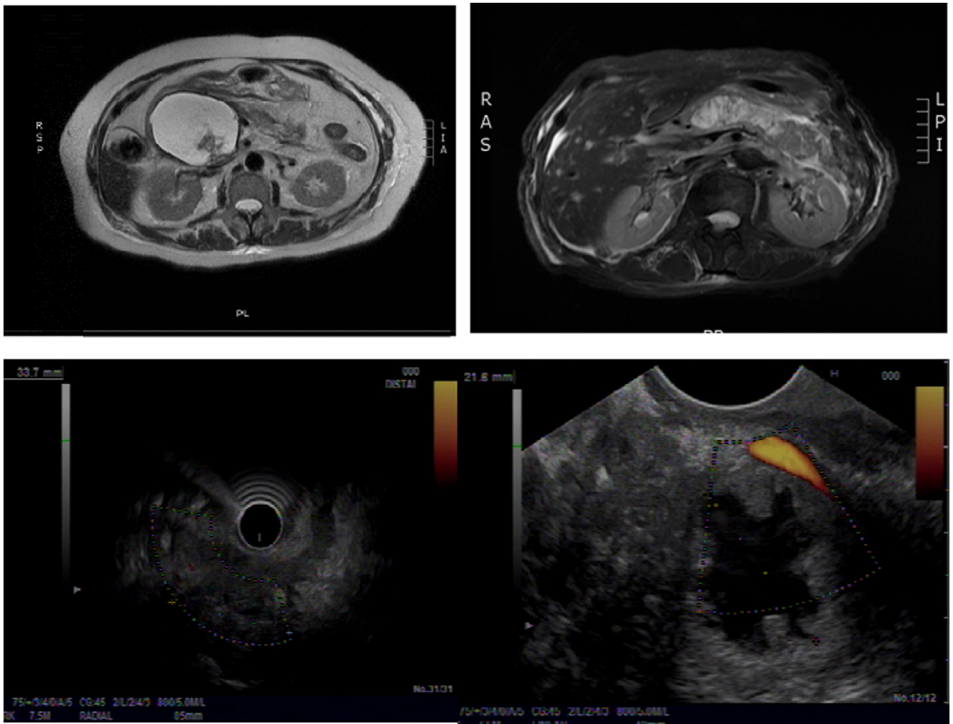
Necrotic soild component of WOPN on MR image (upper panels) and EUS (lower panels). (Color version of figure is available online.)
